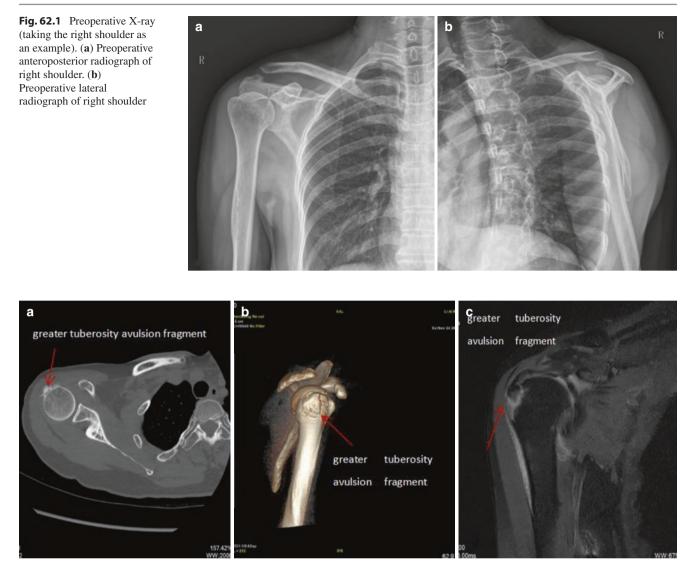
(a) Preoperative CT transverse plain scan of shoulder. (b) Preoperative CT three-dimensional reconstruction image of shoulder. (c) Preoperative coronal plain MRI images of shoulder
